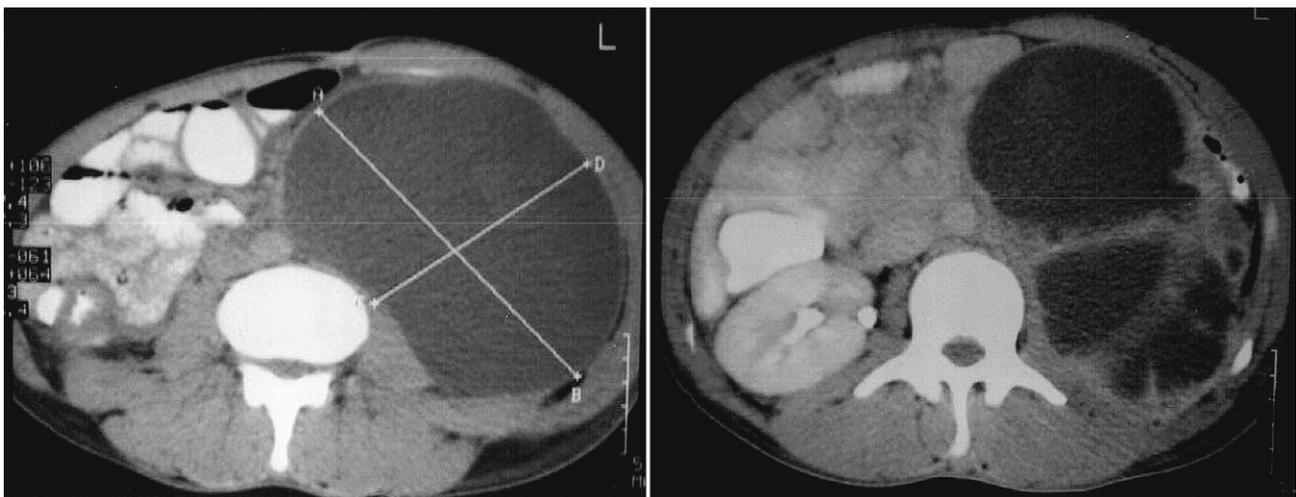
Left, Transverse computed tomography scan of a large left cystic mass (giant urinoma). Right, Giant urinoma in the left is seen with multiple septa.
